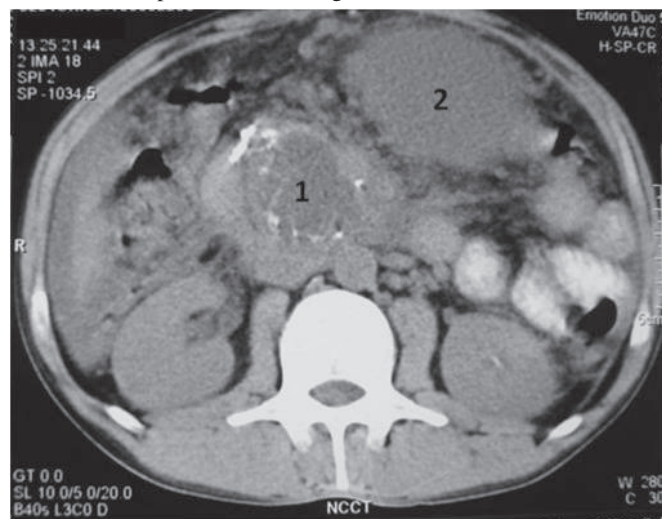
Computed tomography scan showing two pseudocysts—one in the head region (1) with calcification of its wall and the other in the lesser sac (2).
